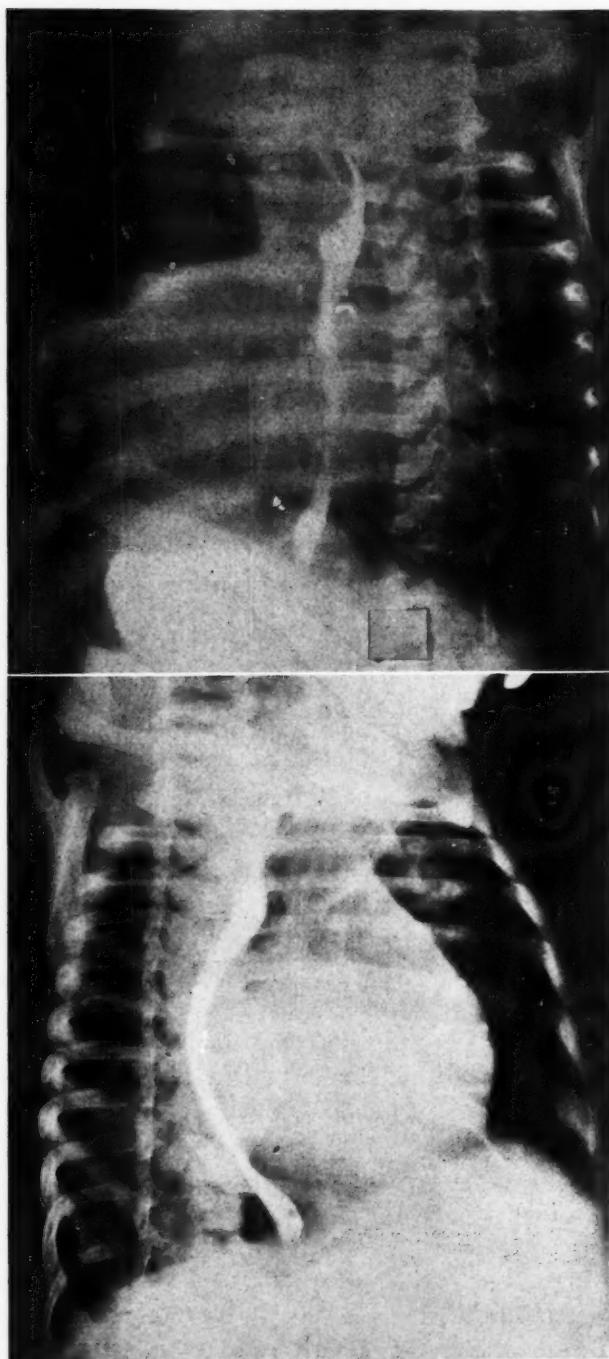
X-ray of heart in Case 1 of left (A) and right (B) anterior oblique positions.
